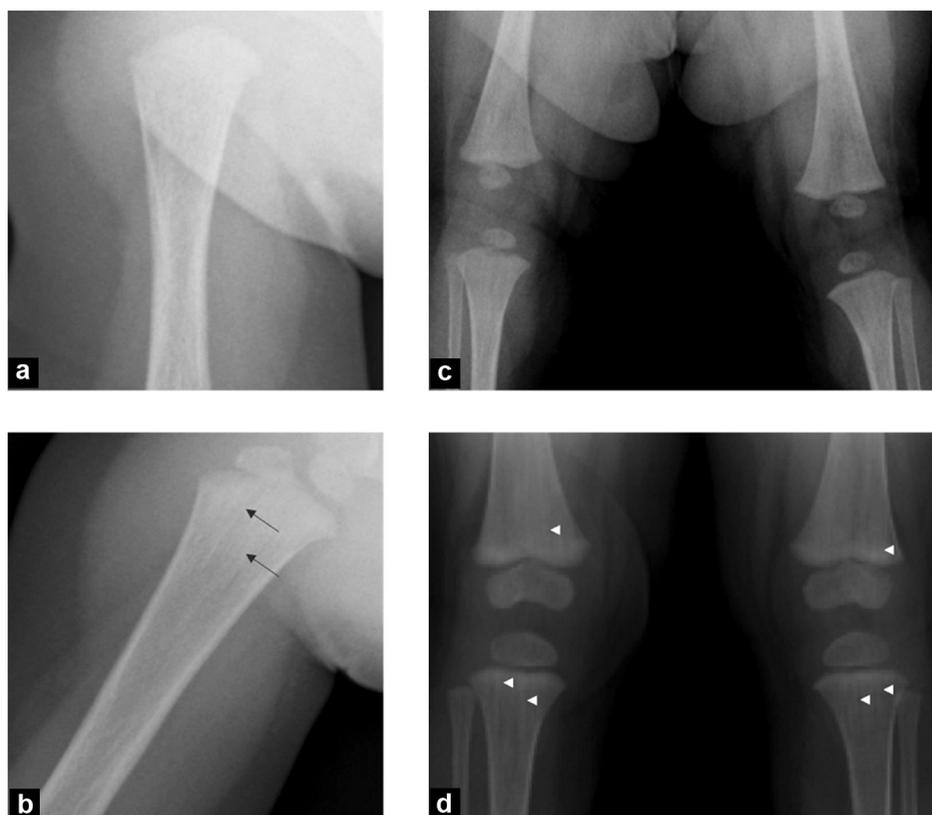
a: Anterior–posterior views of the proximal humerus bone at 4 months showed no visible abnormalities; b: Definite linear striations (arrows) of the humerus bone are observed at 18 months; c: X-ray image of the lower extremities at 4 months shows non-specific sclerosis; d: Linear striations (arrowheads) become evident in the metaphyseal areas of the femur and tibia bones at 18 months.
